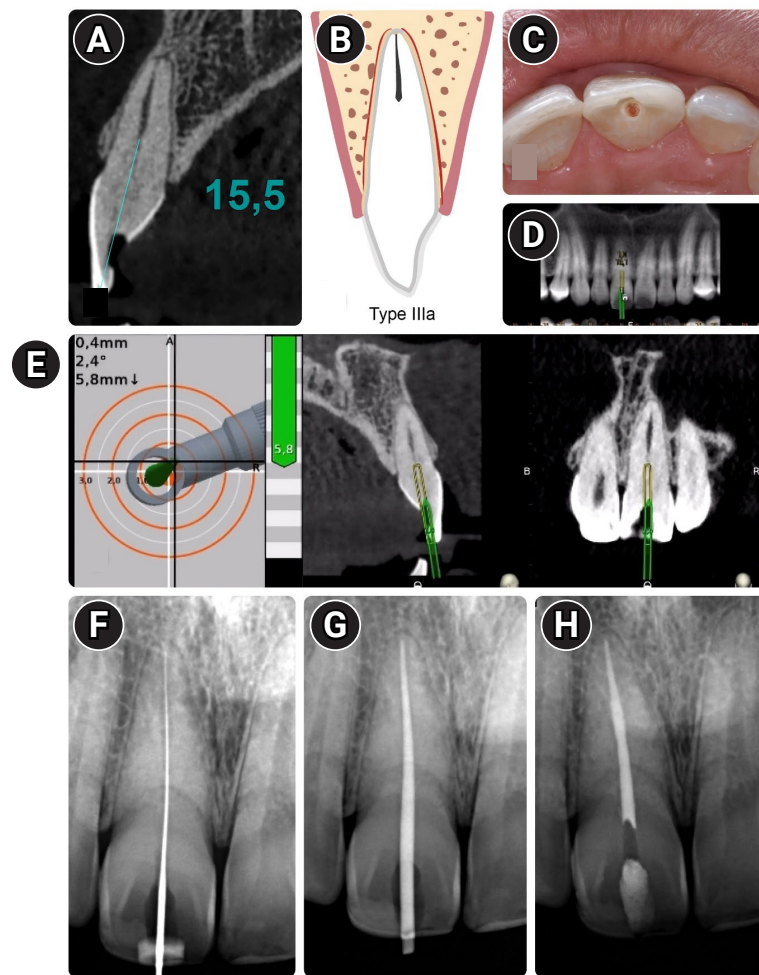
Characteristics of Type IIIa root canal classification. (A) Tomographic image. (B) Type IIIa classification scheme. (C) Access to pulp chamber/root canal. (D) Planning for pulp chamber/root canal access coronal slice. (E) Navident (ClaroNav Inc., Toronto, ON, Canada) graphical interface for root canal access planning. (F) Initial radiograph. (G) Gutta-percha master point fitting before root canal filling. (H) Filled canal.
